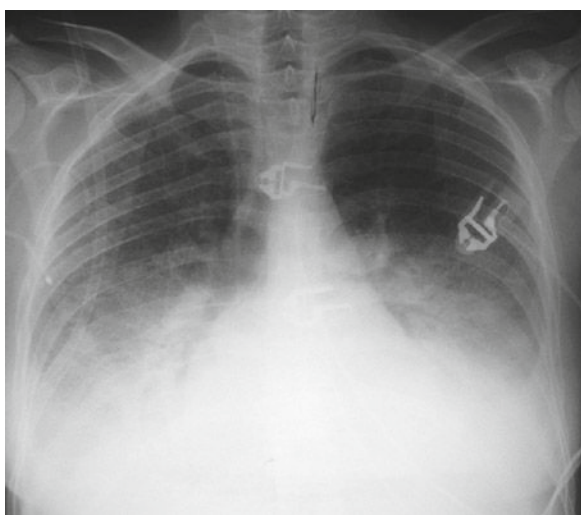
Chest X-ray showing bilateral mid and lower lung field opacities with blunting of the lateral costophrenic angles
